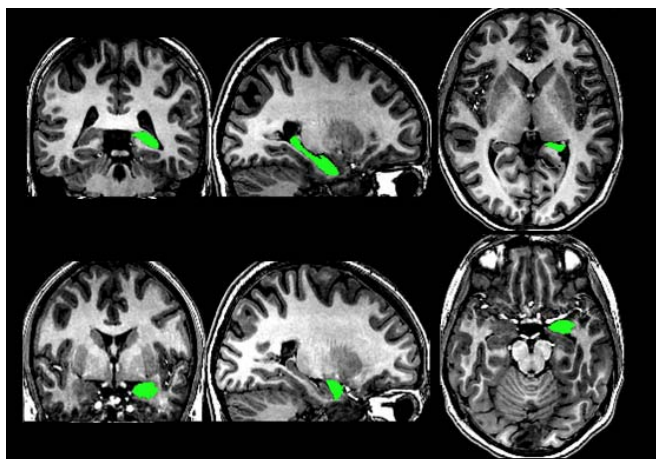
The delineation of right hippocampus (upper panel) and amygdala (lower panel) on high-resolution T1-weighted images.
